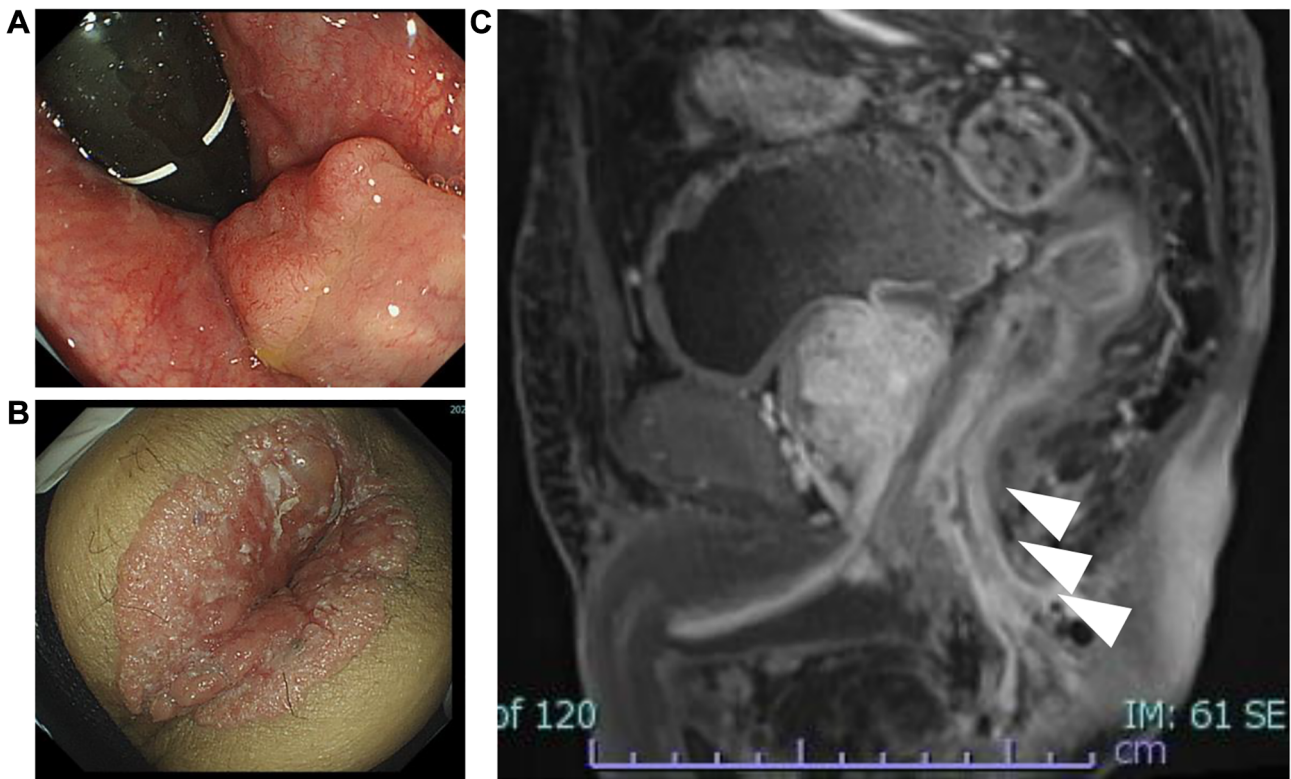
Examination findings of the lesion A) Colonoscopy image showing a flattened, elevated lesion measuring 15 mm in size in the anal canal. B) Colonoscopy image showing full circumferential anal lesions extending to the anal canal. C) Magnetic resonance imaging T1-weighted sequence 1 revealing mild wall thickening measuring 55 mm in the lower rectum (arrowhead), with no significant lymphadenopathy.
